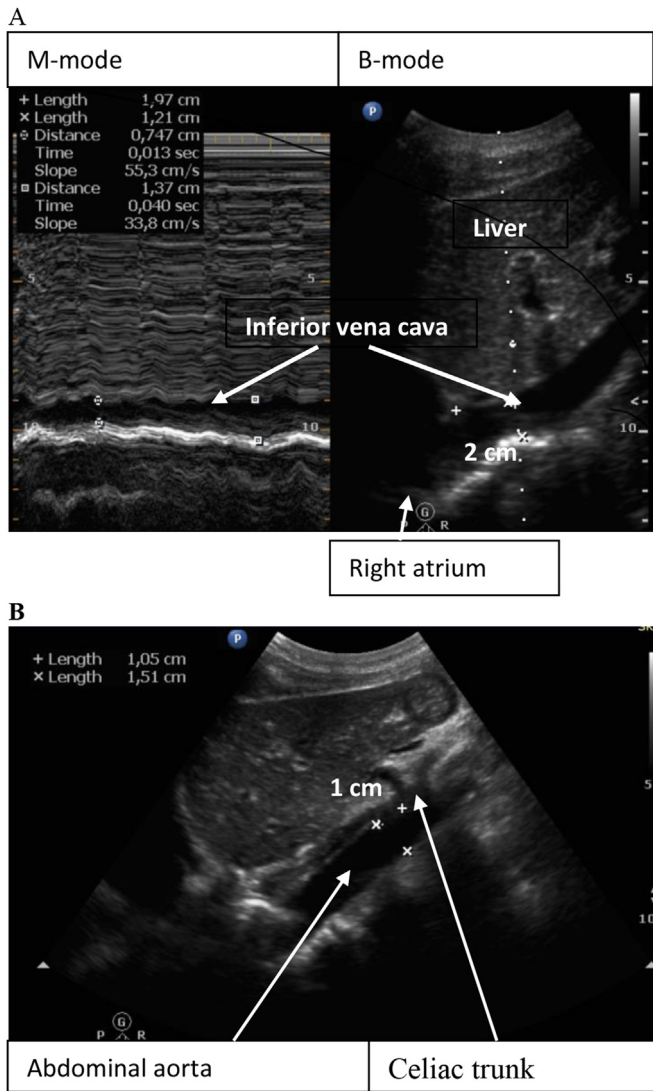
Visualization of IVCD by ultrasound
